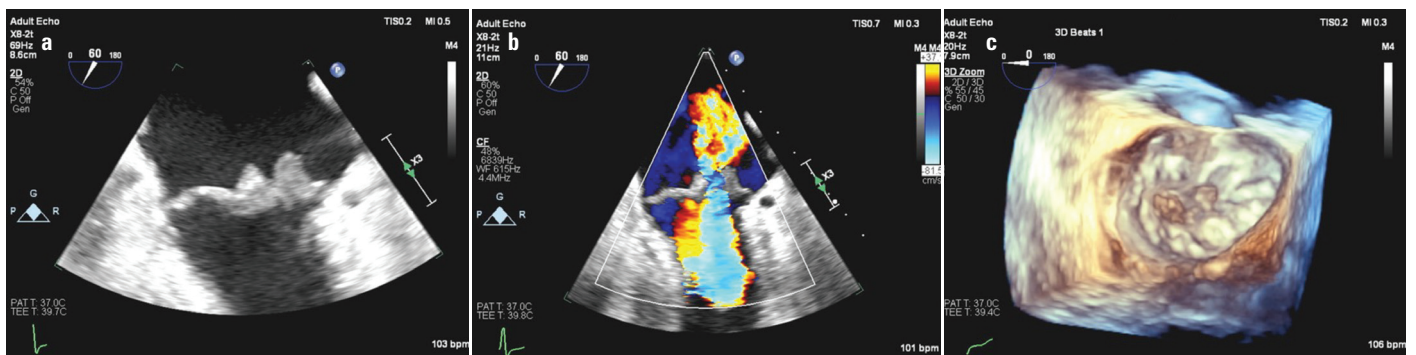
(a) Transesophageal echocardiogram demonstrating a 1.4×0.9 cm mass on the P2 leaflet and a 1.3×0.8 cm mass on the A2 leaflet. (b) Color Doppler image demonstrating moderate-severe mitral valve regurgitation. (c) 3-dimensional transthoracic echocardiogram demonstrating a 1.4×0.9 cm mass on the P2 leaflet and a 1.3×0.8 cm mass on the A2 leaflet
